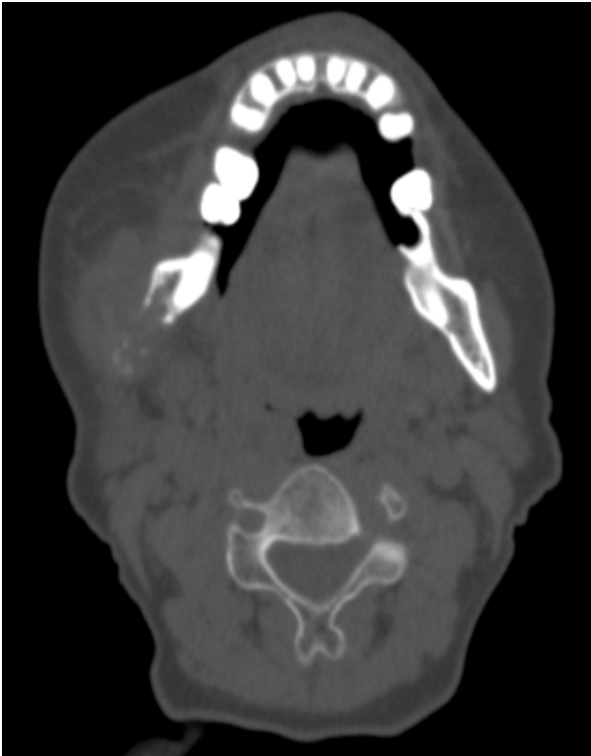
CT axial image-Bone window
